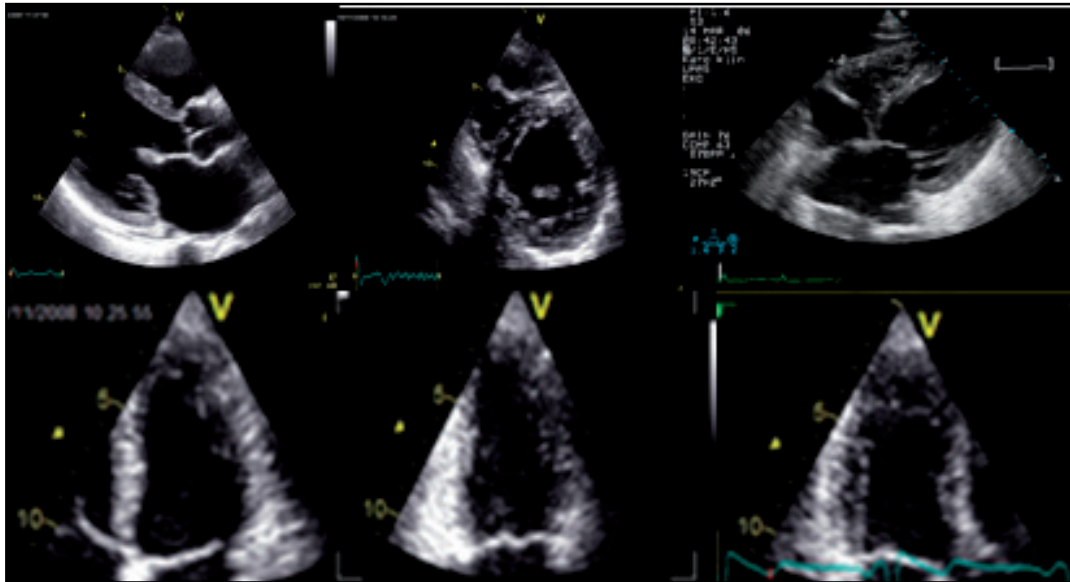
Echocardiographic views. From top left: parasternal long-axis view, parasternal short-axis view at the mid level, subcostal view, apical four-chamber view, apical two-chamber view and apical three-chamber view.
